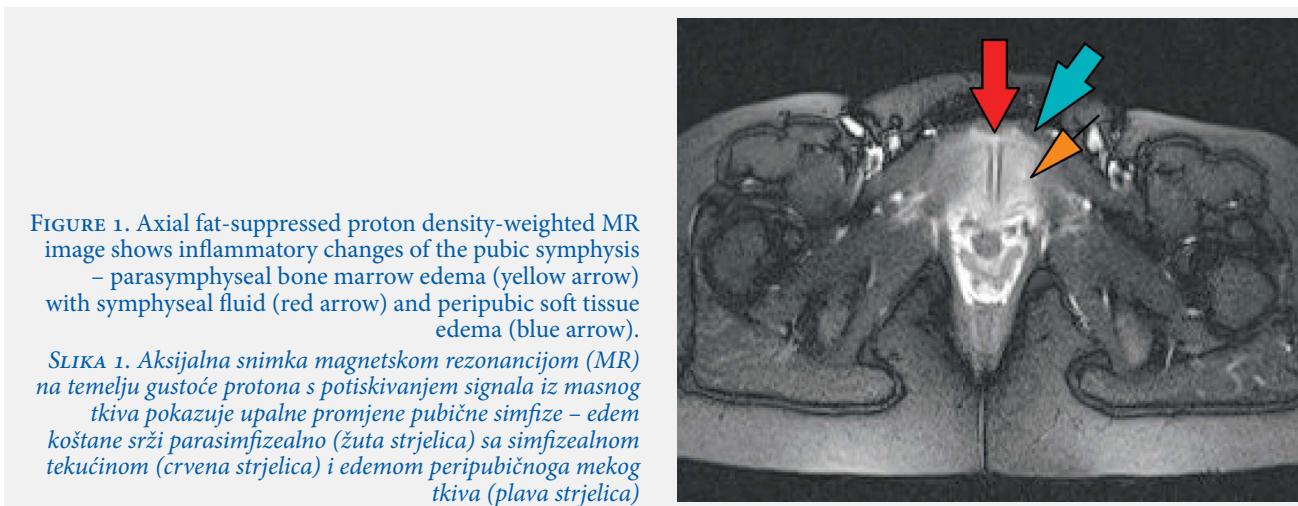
Axial fat-suppressed proton density-weighted MR image shows inflammatory changes of the pubic symphysis
